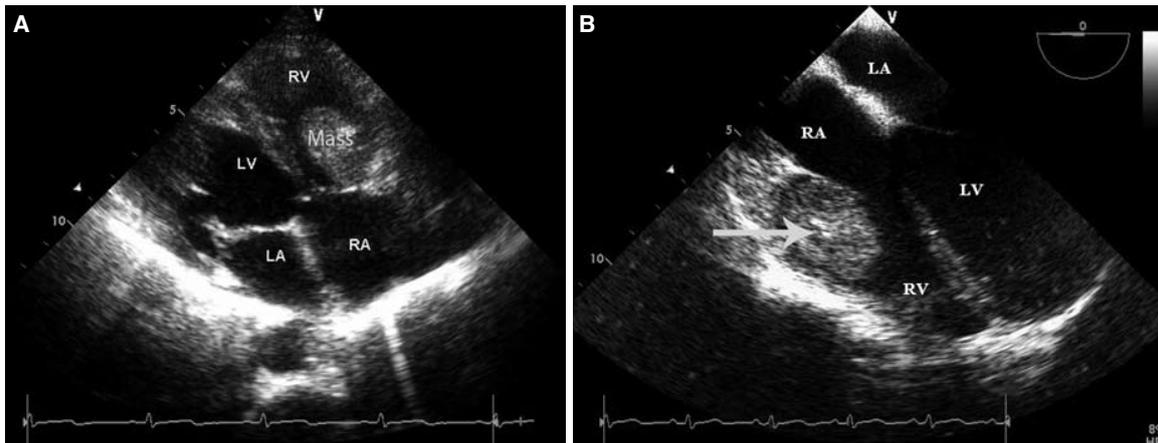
(A) Transthoracic apical four-chamber and (B) transesophageal views showing the mass in the right ventricle. LA: Left atrium; LV: Left ventricle; RA: Right atrium; RV: Right ventricle.
